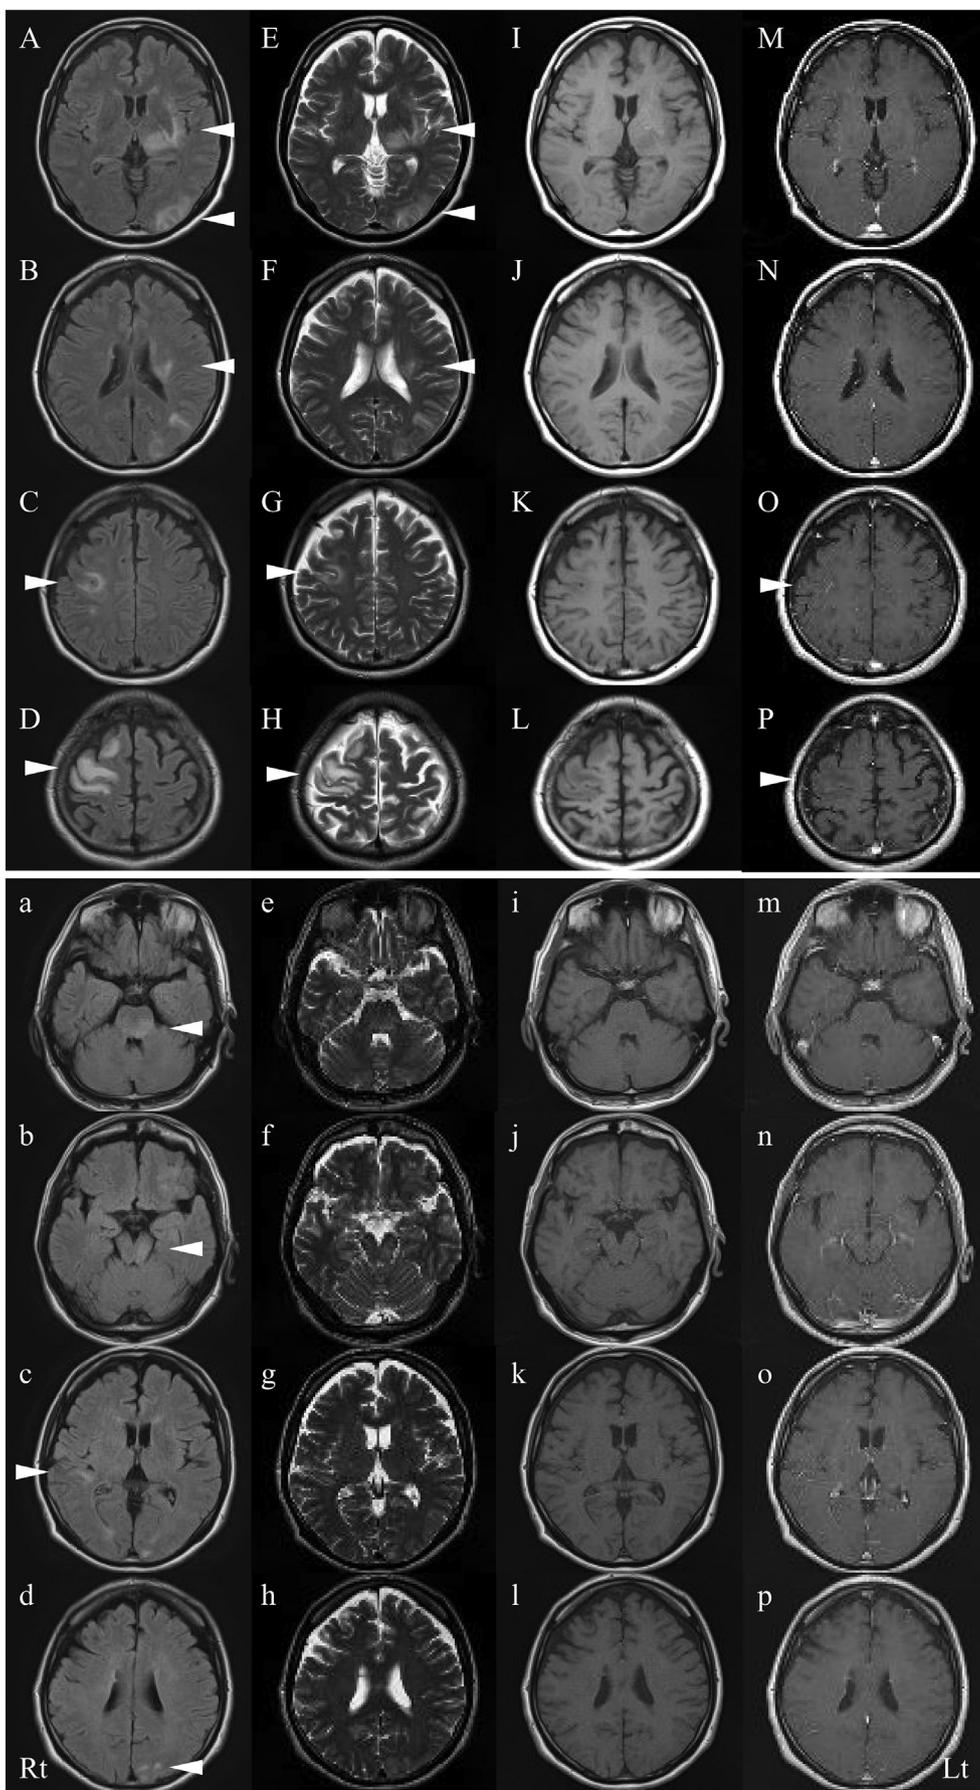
(Upper panel) Head MRI (Toshiba, 1.5 T) scan showing multiple lesions in the right frontal lobe, the subcortical white matter of the left parieto-occipital lobe, the bilateral para-hippocampal gyrus, the left thalamus, the left external capsule, and the left corona radiata; there was also high signal intensity on fluid-attenuated inversion recovery (FLAIR) (TR 6000 ms, TE 105 ms) (A-D) and T2-weighted images (T2WI) (TR 3800 ms, TE 105 ms) (E-H) and slightly low signal intensity on T1-weighted image (T1WI) (TR 600 ms, TE 15 ms) (I-L). Slight contrast enhancement was observed in the right frontal lobe lesion (M-P). (Lower panel) Head MRI on FLAIR (TR 6000 ms, TE 105 ms) (a-d) and T2WI (TR 6800 ms, TE 105 ms) (e-h) showing high signal intensity regions in the right temporal lobe, the left frontal lobe, the left occipital lobe, the left pons, the left midbrain, and the left middle cerebellar peduncle at relapse. No clear contrast enhancement was observed on T1WI (i-p).
